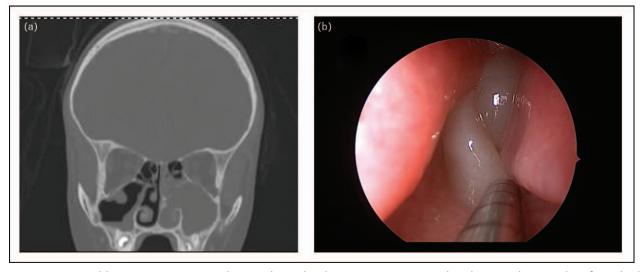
8-year-old patient presenting with antrochoanal polyp seen on CT (a) and endoscopy (b) extending from the left maxillary sinus.
